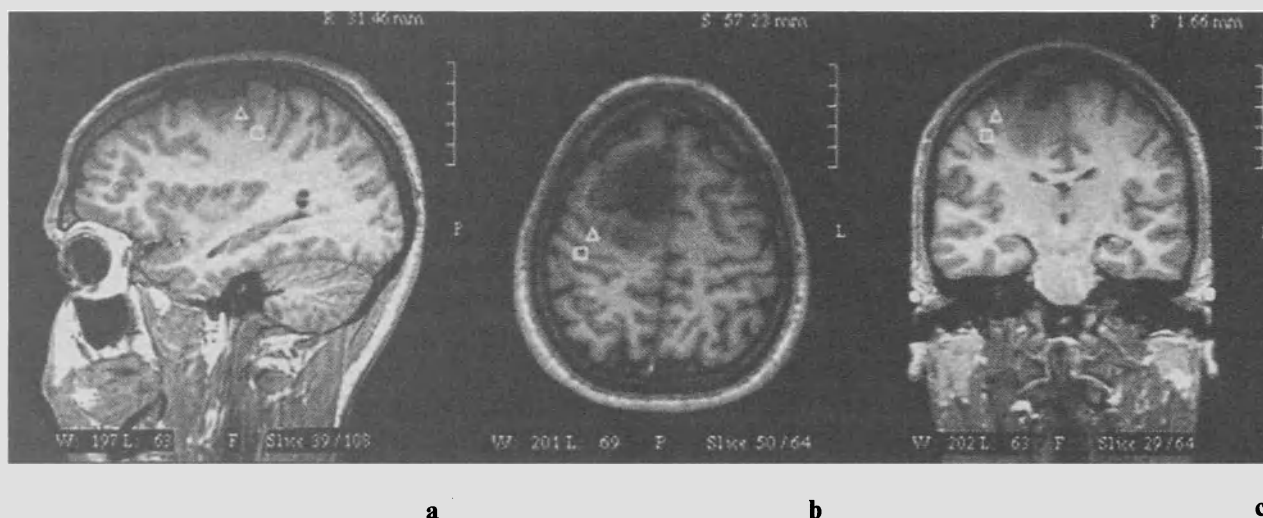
(a-c) Patient data: Localization of sensorimotor cortex in an adult with a right frontal lesion. The patient is a 24 year old left-handed male who presented with a 2 year history of focal as well as generalised seizures. Neurological testing revealed no deficits. Imaging studies demonstrated a large, irregularly shaped hypodense lesion in the right frontal lobe. Preoperative MEG mapping was performed revealing index finger motor (triangle) and thumb sensory (square) dipole sources. These sources are shown projected onto sagittal (a), axial (b), and coronal (c) MRI images. On the basis of MEG localization of the central sulcus, the tumour was determined to be immediately anterior and adjacent to, but not involving, the motor cortex
